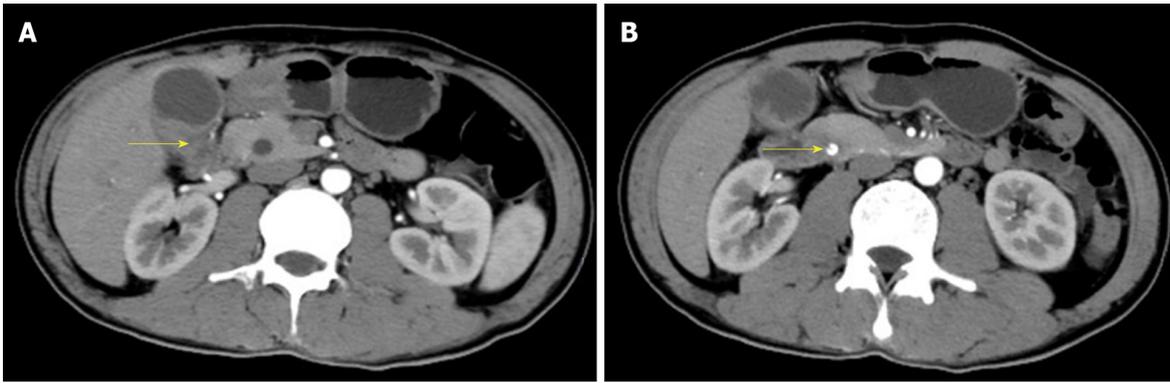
Enhanced computed tomography imaging. A: Thickening of the gallbladder wall and irregular density soft tissue extending from the neck and invading into the cavity and intrahepatic bile ducts with intrahepatic bile duct dilatation by approximately 2.5 cm × 1.3 cm; B: The cystic duct lumen was narrowed and a circular calcification-like high-density shadow was visualized at the end of the common bile duct at approximately 0.8 cm.
